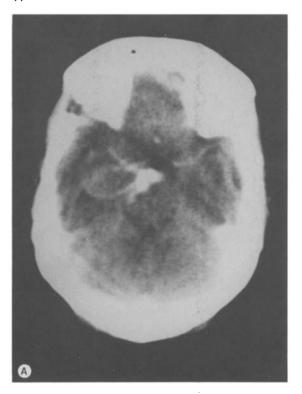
A CT scan obtained 14 days after the first course of chemotherpy. Notice the homogenous enhancement of the entire cyst after the intravenous injection of contrast. The cyst appears to be smaller.
